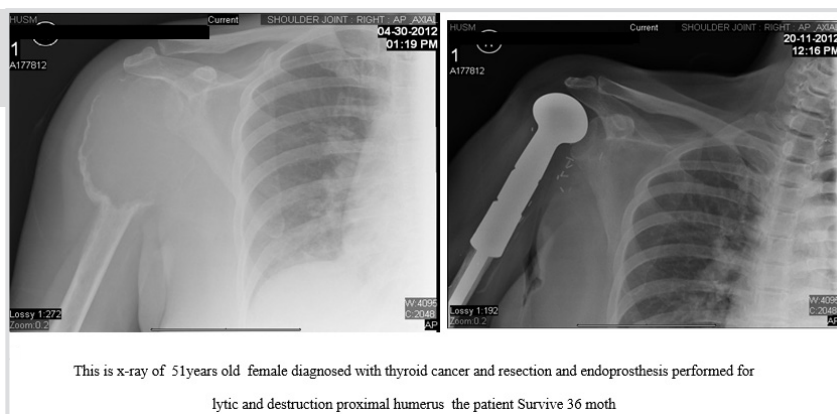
Resection and endoprosthesis placement were frequently performed in this x-ray.
